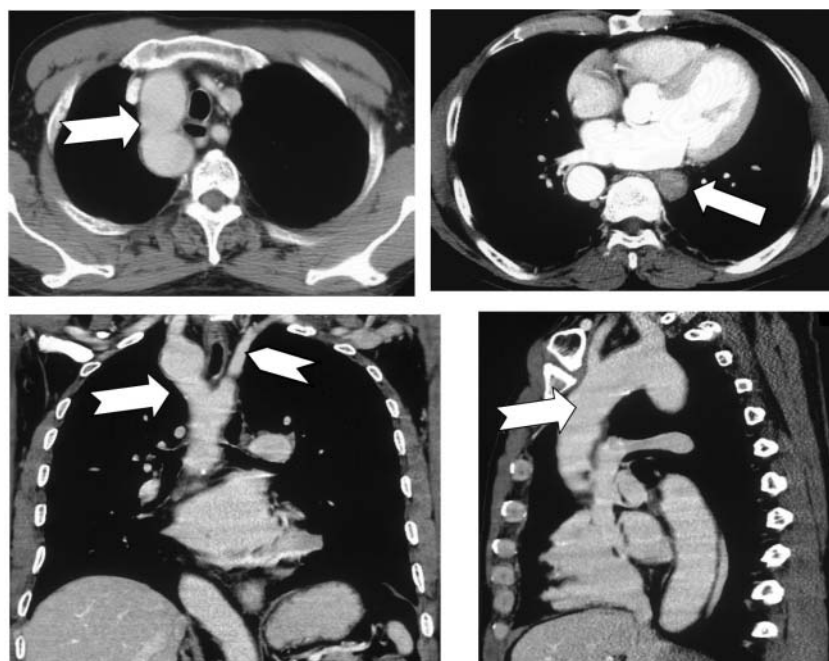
Chest computed tomography. A 5-cm long circumferential wall-thickness of the esophagus was recognized in the lower thoracic esophagus (⇨). The right aortic arch (⇨) was demonstrated with an aberrant subclavian artery (⇨).
